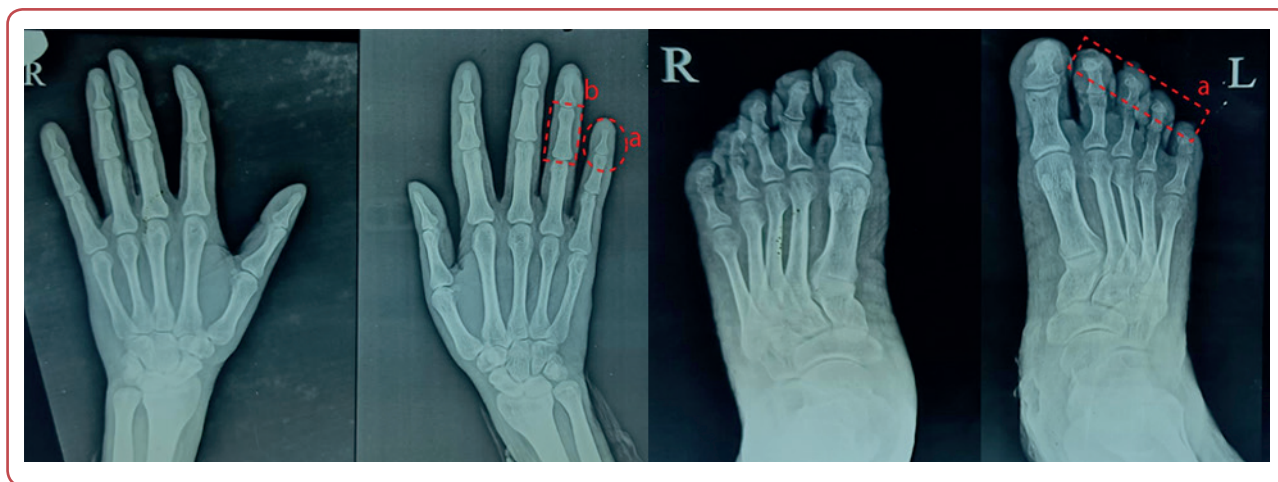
X-ray of the hands and feet (AP) showing: a) resorption of terminal phalanx of 5th digit with subarticular erosion of middle phalanx of left hand, resorption of most of the terminal phalanges of both feet; b) periarticular osteopenia seen in multiple interphalangeal joints of both feet; c) osteoporotic changes associated with cortical thinning seen in middle phalanges of 2nd, 3rd, 4th and 5th digits and metacarpals of left hand.
